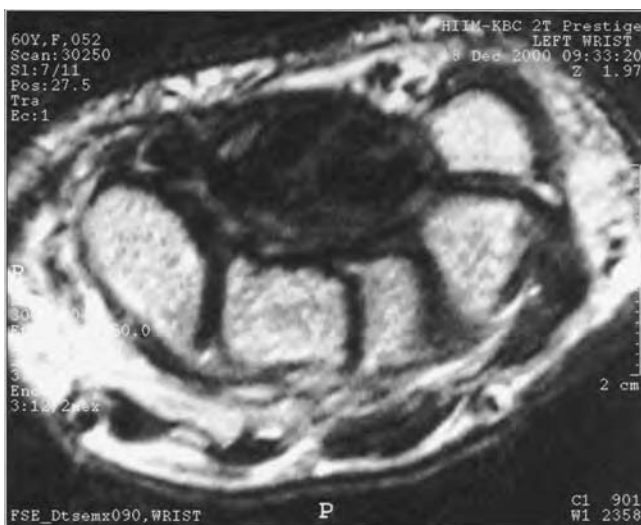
MRI demonstrates high signal intensity as a sign of swelling of the median nerve on FSE T2-weighted image with flattening of the nerve.
